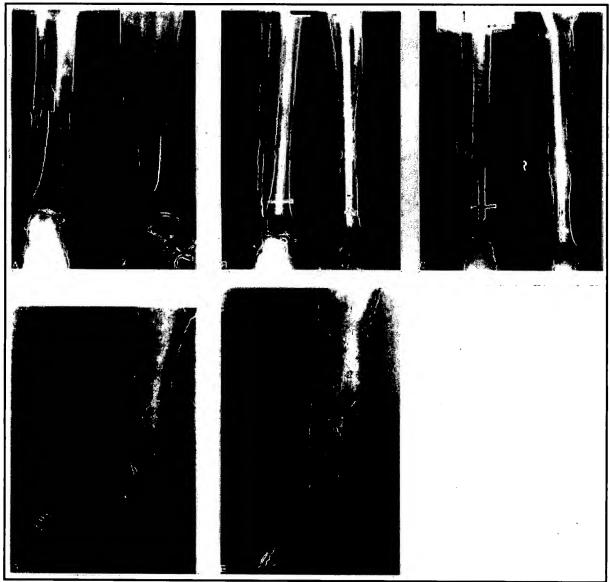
Grade IIIB open tibial fracture after a road traffic accident: (A) initial radiographs, (B) two months after fixation, and (C) fracture completely united 6 months postinjury. Same patient at the time of final followup showing range of ankle motion: (D) dorsiflexion, and (E) plantar flexion.
